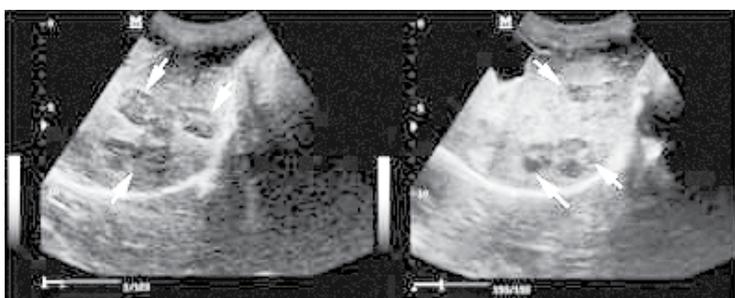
Many masses in ultrasonographic examination of liver (arrows).
